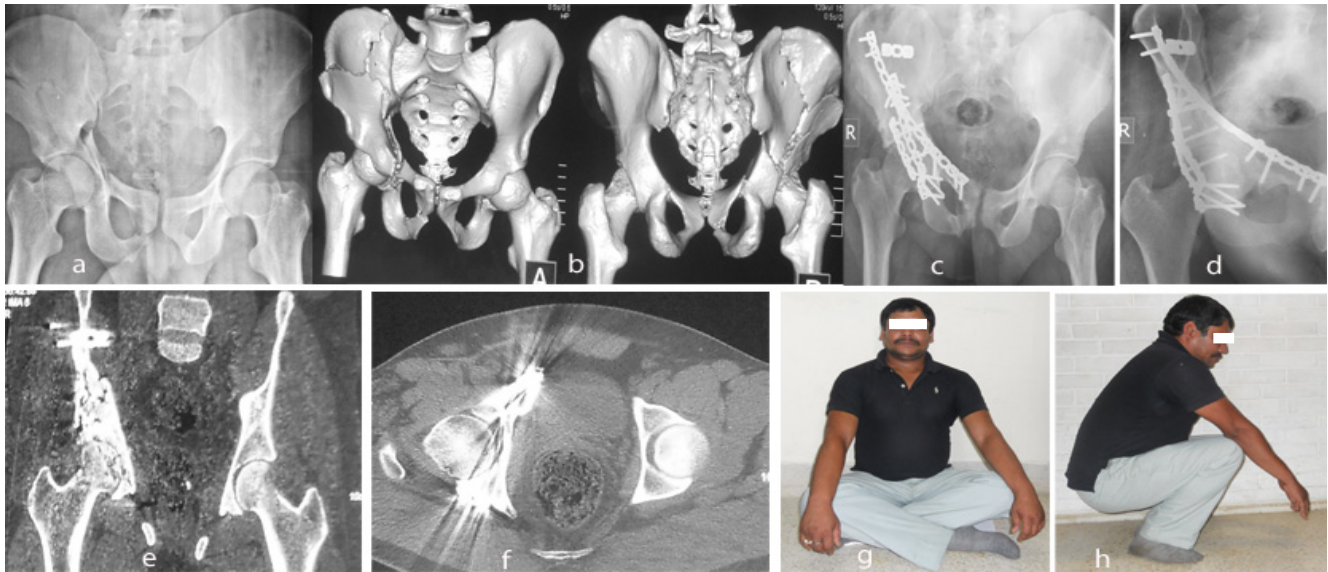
Bicolunar fracture with bicolunar fixation. a,b: Pre operative Xray and CT scan, c to h: Follow up X-rays and CT scan and clinical picture at 48 months (Note irregularity of acetabular cartilage)
